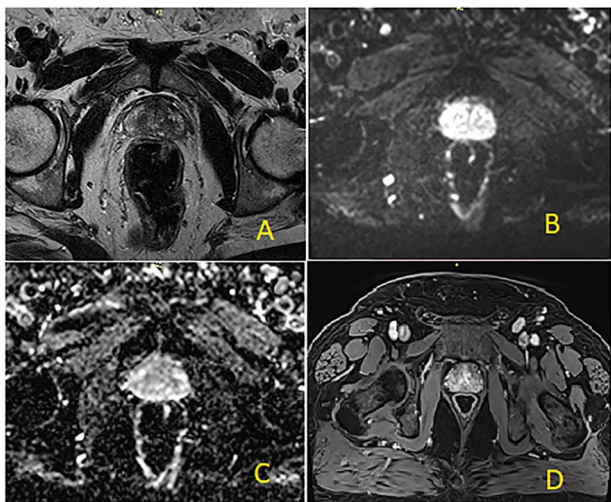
MRI findings in normal ranges A. T2-weighted imaging (T2WI), B. diffusion-weighted imaging (DWI), C. ADC map and Dynamic contrast enhancement (DCE), D. T1-weighted fast spoiled gradient echo.
